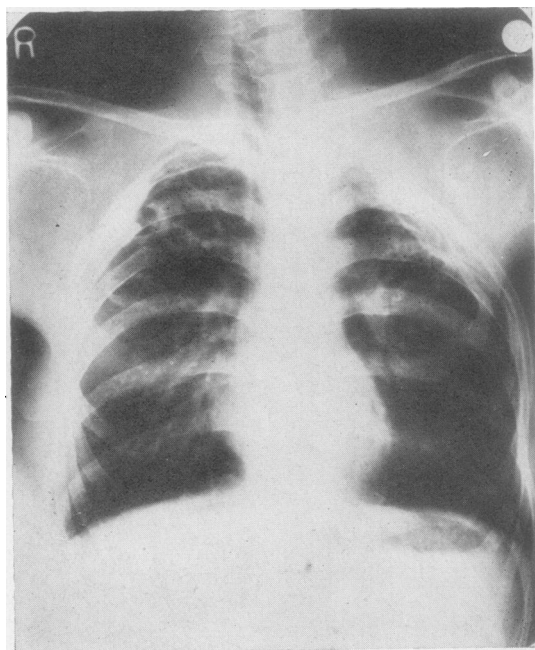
Radiograph at conclusion of treatment. Six months after the left thoracoplasty a one-stage operation with refills was carried out on the right side. Gastric washings and laryngeal swabs were negative on culture on discharge.
